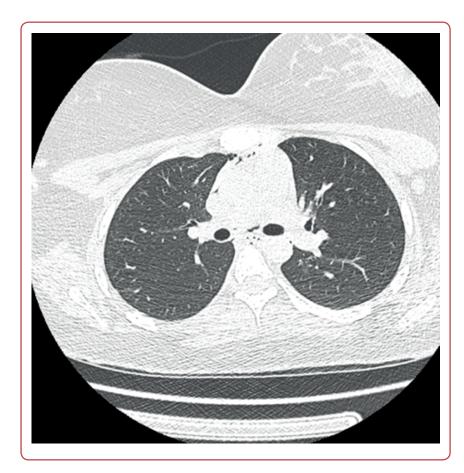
Chest computed tomography (CT) scan axial cut showing regression of pneumomediastinum
